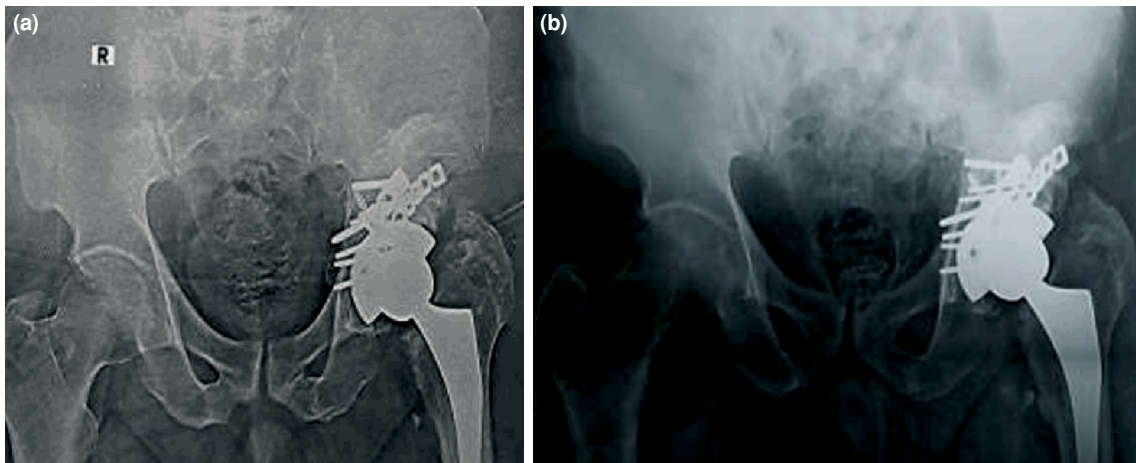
Postoperative X-ray showing the total hip arthroplasty. (a) Immediate postoperative X-ray view. (b) Following an 18-month follow-up.
